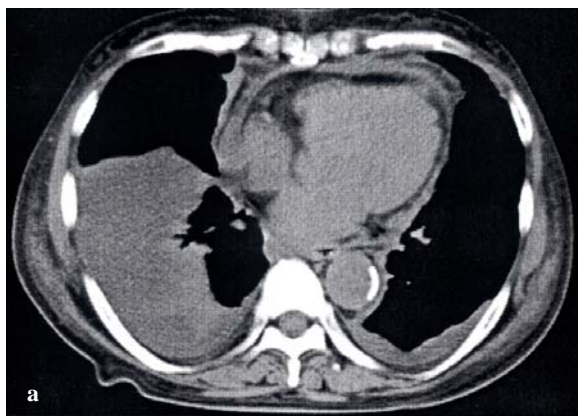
Chest CT showed the exacerbation of right pleural effusion 1 week after starting prednisolone (PSL) (30 mg/day) treatment, b) Abdominal CT showed ascites.
